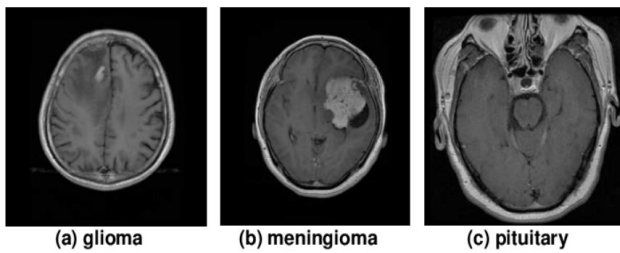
Sample of the brain tumor MRI dataset for the classes: (a) glioma, (b) meningioma, (c) pituitary, [28].
